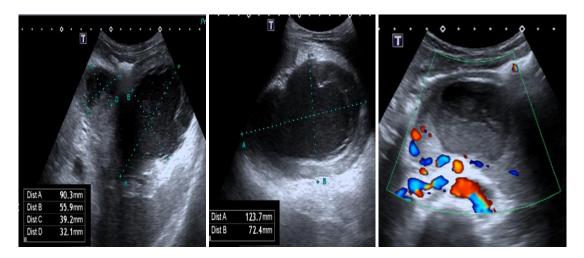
a, b, c. The ultrasound (US) images (a, b) show two thick-walled hemorrhagic pancreatic pseudocysts containing multiple echogenic materials in the pancreatic parenchyma and peripancreatic location. In Color Doppler US (c) no vascularization was seen in the lesions.
